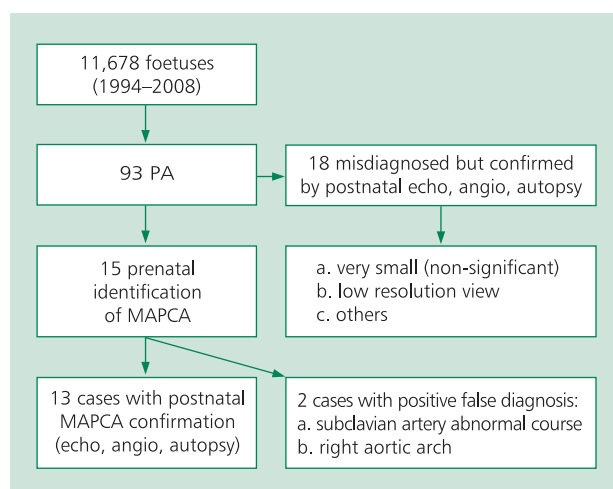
Foetuses retrospectively analysed; PA — pulmonary atresia; MAPCA — major aortopulmonary collateral artery; echo — echocardiography; angio — angiography
